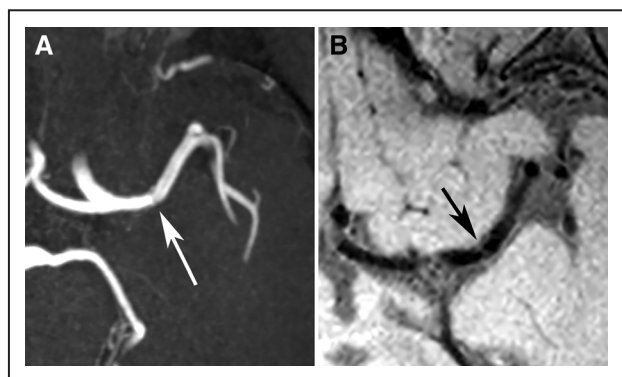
A 64-year-old male patient presented with a left partial anterior circulation infarct caused by a left middle cerebral artery (MCA) stenosis. A, Transverse time-of-flight magnetic resonance angiography shows a small stenosis in the left MCA (white arrow). B, On the transverse T1-weighted volumetric isotropically reconstructed turbo spin echo acquisition image, no corresponding vessel wall lesion was found (black arrow).
